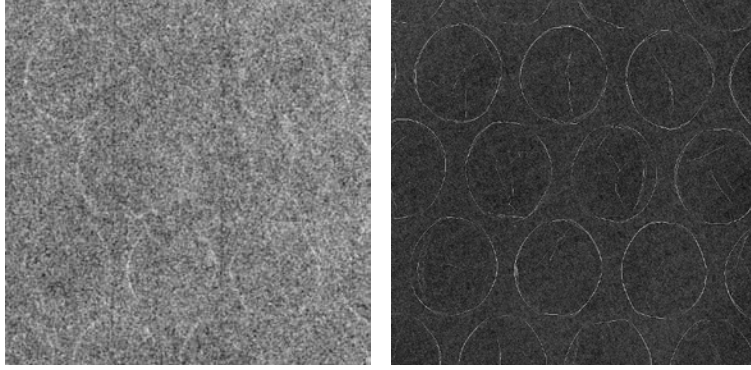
Nylon air bubble Images acquired at 40 kVp, SID = 1.75 m. (left) Conventional radiograph. (right) Phase-contrast image,  $M = 2.8$ .
